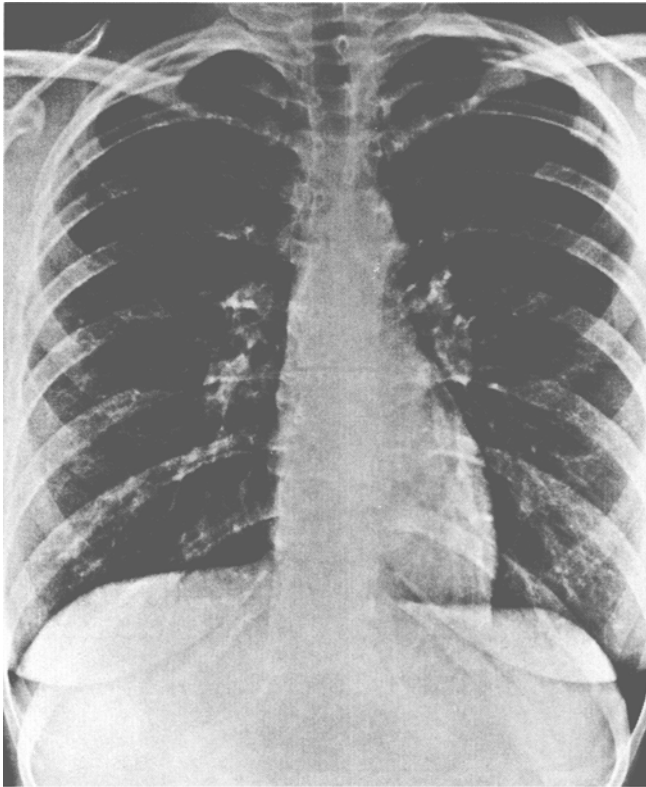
Chest roentgenogram showing bilateral hilar lymphadenopathy.
